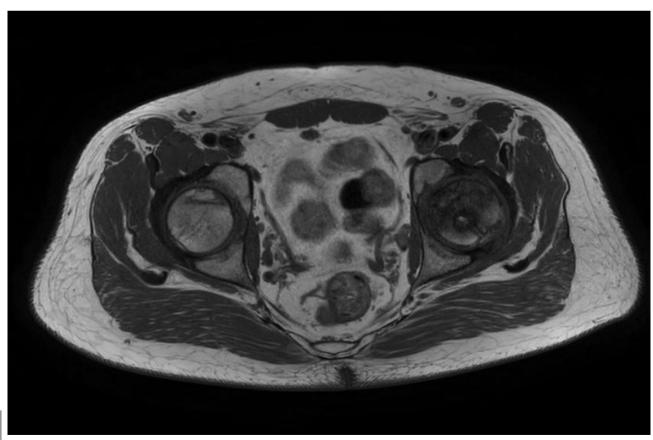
MRI of the hip joints, coronal T1, April 2021. Area of low signal intensity representing oedema in the left femoral head
